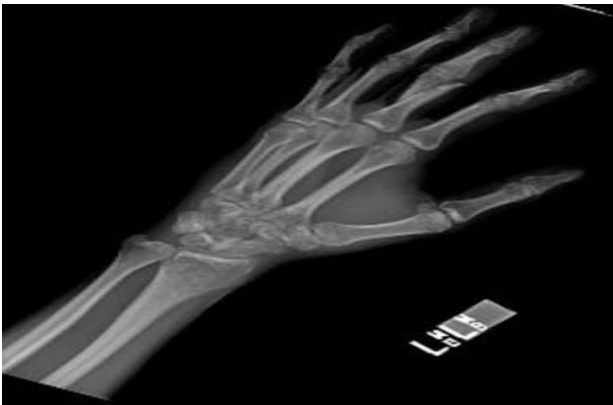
Oblique radiograph of left hand demonstrating displaced oblique fracture of proximal phalanx of the middle digit.
